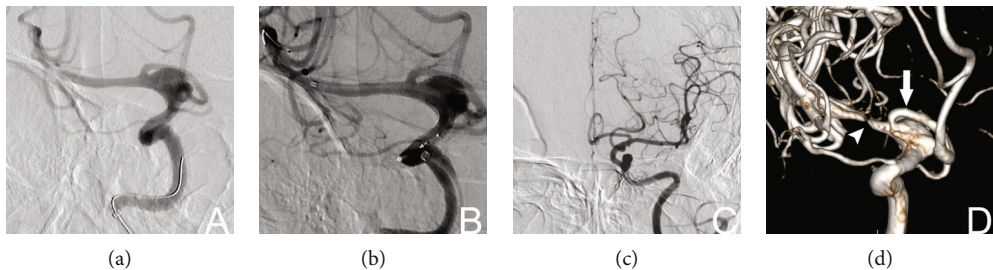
Female patient, 56 years old. CTA images showing that a C7 segment aneurysm was treated with a single PED measuring 3 mm × 25 mm; the sPED/I-ICA ratio was 1.21. The 6-month follow-up angiography showed that a residual aneurysm was present with in-stent stenosis (indicated by the white arrowhead in d), and the patient's mRS score was 2. A1 (indicated by the white arrow in d) is intact. (a, b) The A1 origin was covered before and after PED implantation. (c) Contralateral ICA angiography. (d) Six-month follow-up angiography 3D reconstruction showing that most of the residual aneurysm and A1 remained intact, but M1 shows in-stent stenosis.
